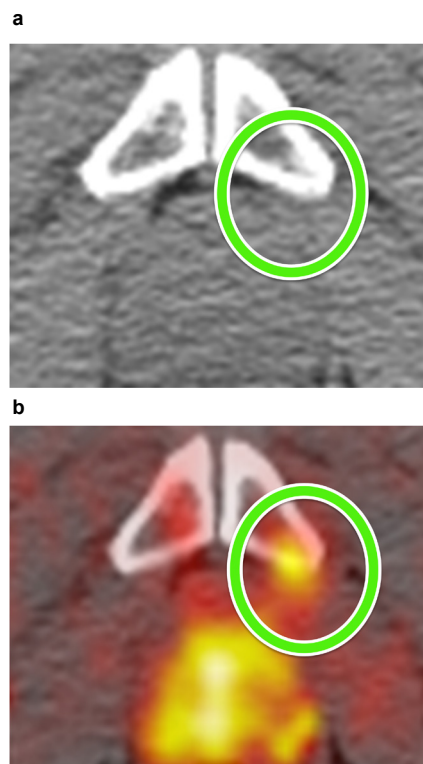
Computed Tomography vs. 11C-Choline
